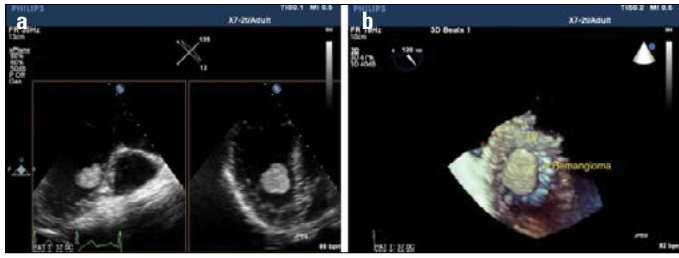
(a) Two-dimensional transesophageal echocardiography image with xPlane shows a faintly visible stalk of the left ventricular mass. (b) Real-time three-dimensional transesophageal echocardiography shows the surface of the mass as slightly irregular.
